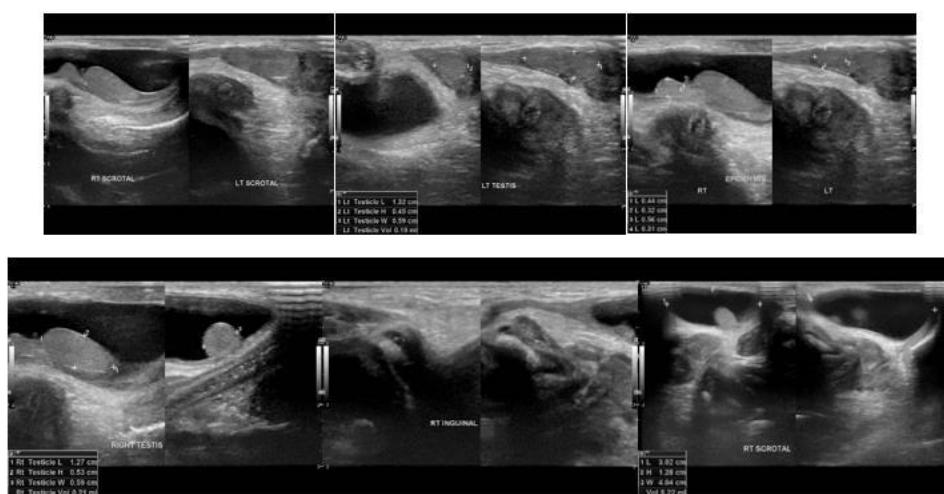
RSMS Testicular Ultrasound (November 13, 2024)
